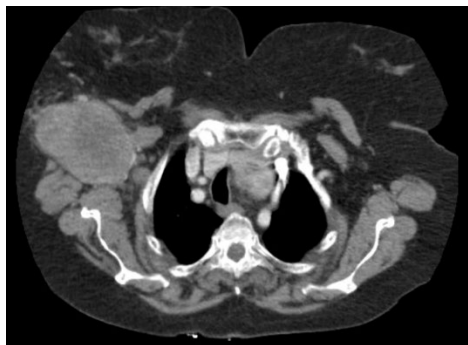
CT scan of the chest revealing a heterogeneous mass in the right axilla measuring 6.9 x 9.5 x 10.6 cm very suspicious for malignancy (*Cont. next page*)
